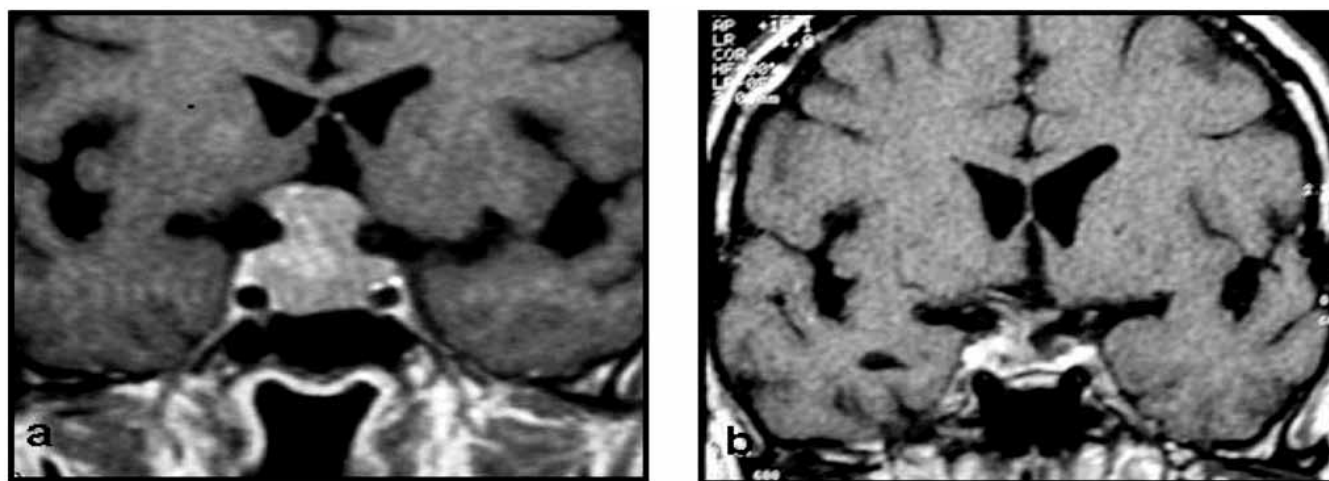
Contrast-enhanced coronal T1-weighted MRI showing a large pituitary macroadenoma with suprasellar extension (patient n.5) (a). Contrast-enhanced coronal T1-weighted MRI six months after transphenoidal surgery: a small residual intrasellar tumor is evidenced.
